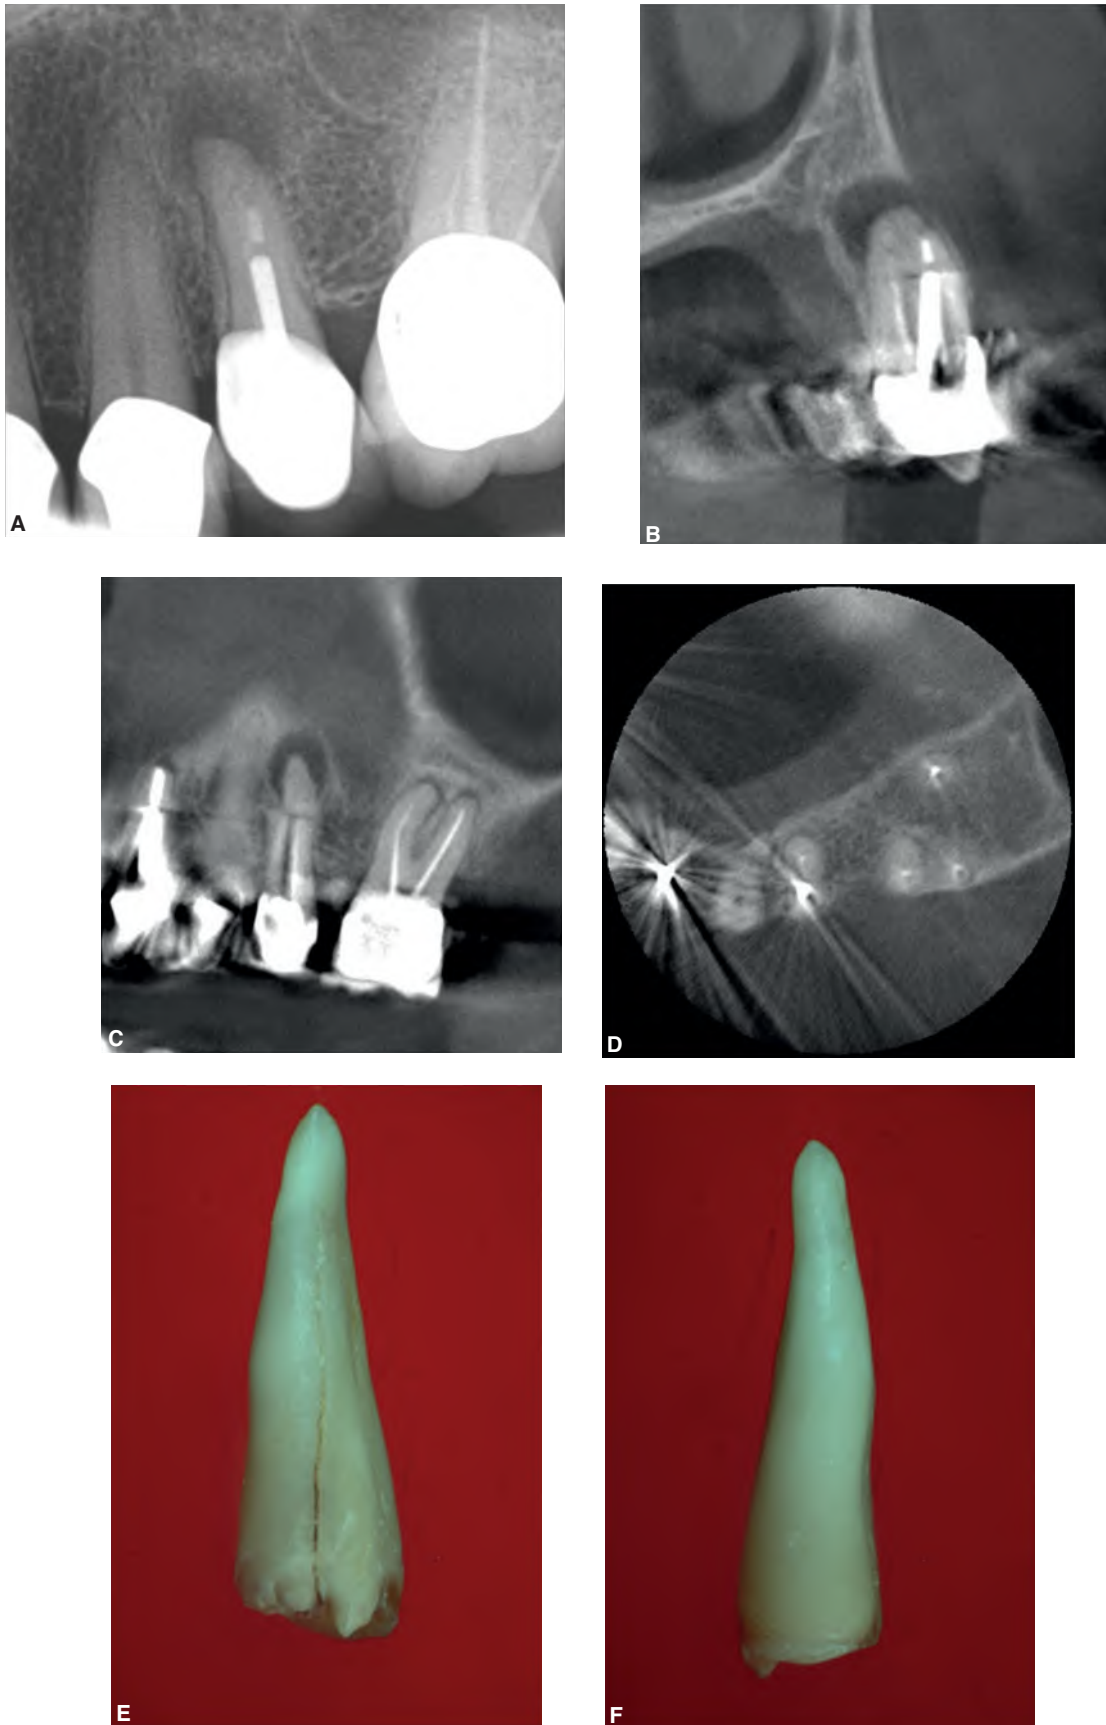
Restored, endodontically treated maxillary premolar. “Halo” radiolucency can be seen around the tip of the root (A). Despite deep probing defect in the midbuccal area, no evidence of fracture can be seen in CBCT coronal (B), sagittal (C) or in axial (D) views. After the tooth was extracted, the VRF can be seen clearly in the buccal aspect of the root (E) but not in the lingual one (F). (Courtesy of Dr. Ron Ganik, New York, NY.)
